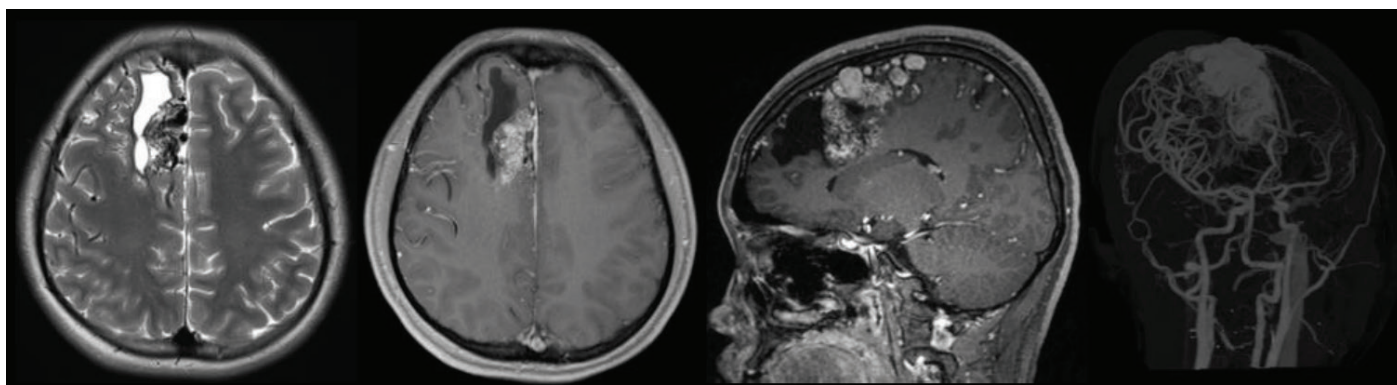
Brain magnetic resonance imaging and MRA revealing the nidus with a tortuous and ectatic draining vein in the paramedian frontal region
